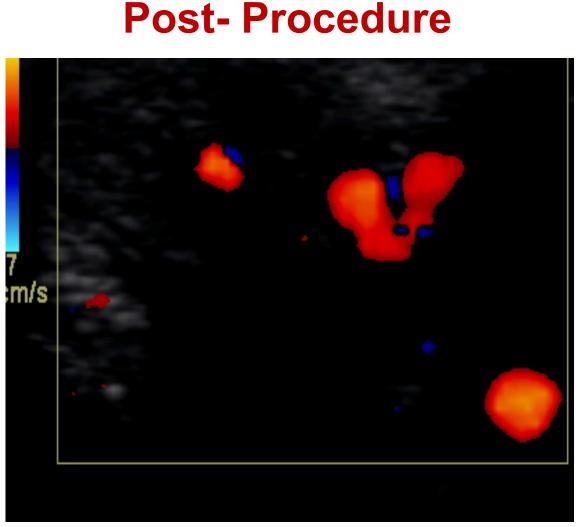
Images of Penile Doppler before and 6 months after undergoing Erectile dysfunction shockwave therapy
